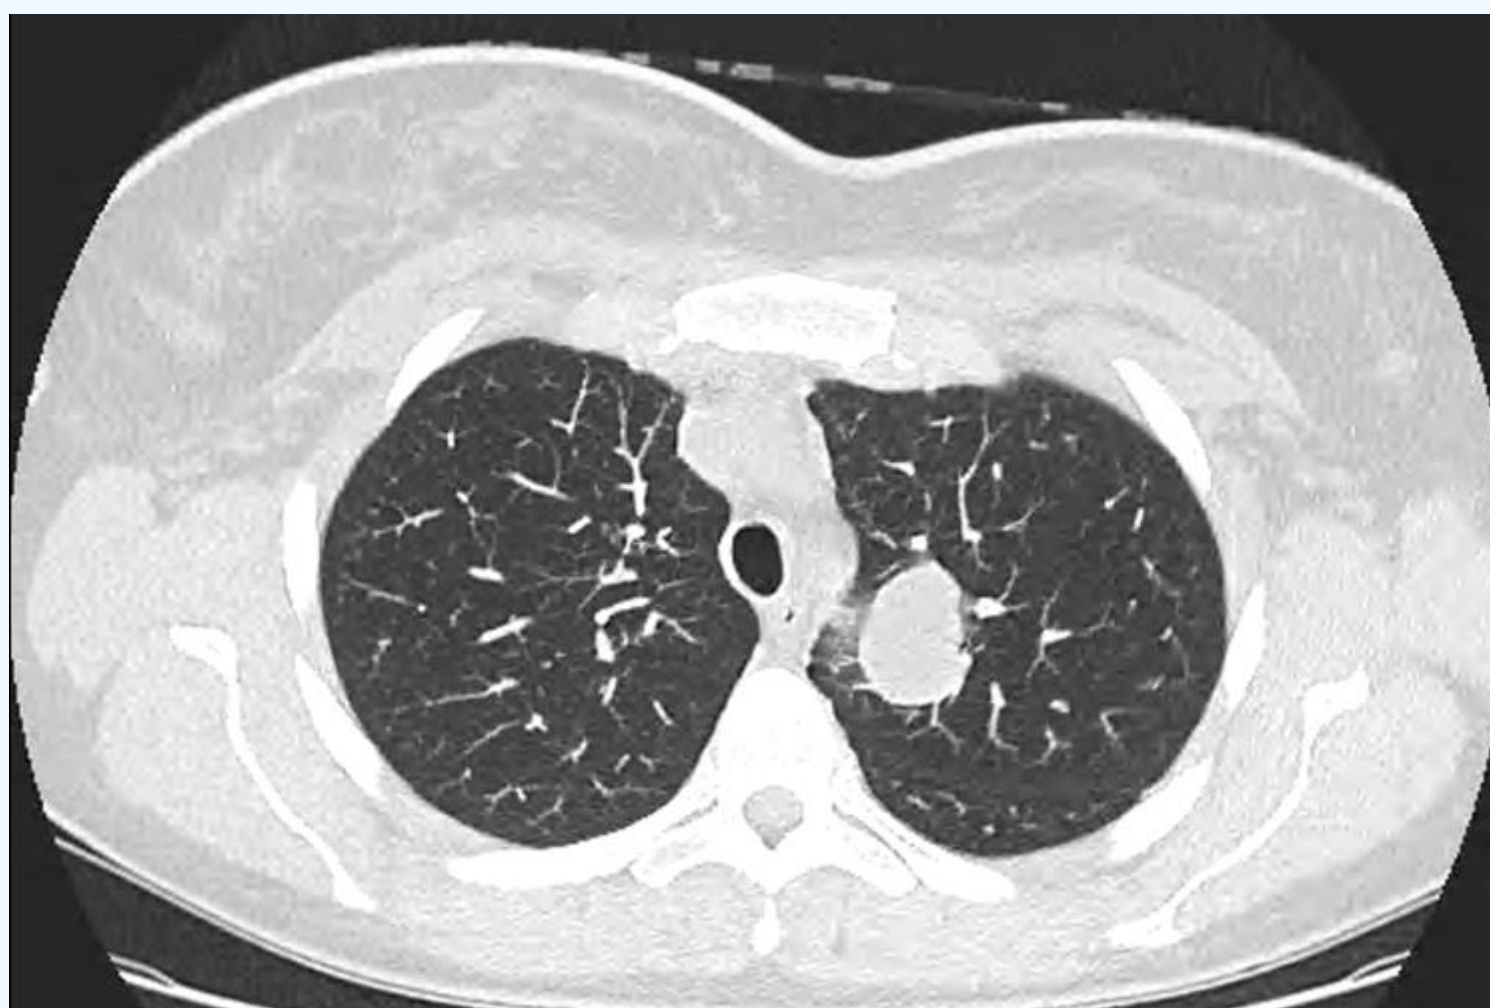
CT demonstrating left upper lobe lung metastases
